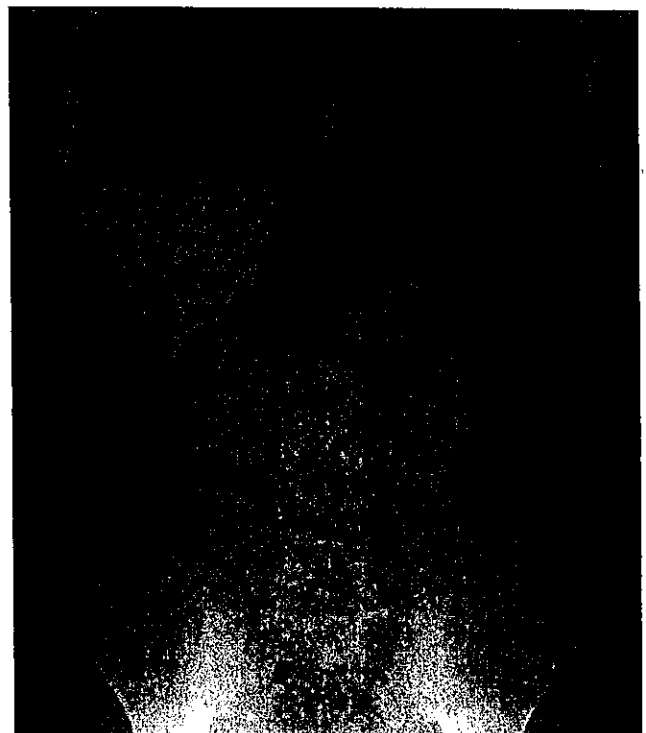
Abdominal radiograph of a 13-year-old boy with congenital Chagas disease, Japan, showing megacolon and marked dilatation at the splenic flexure.
